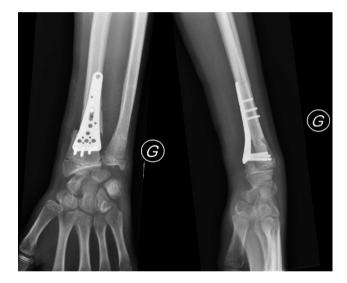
Patient #1, antero-posterior and lateral radiographs after surgery.
